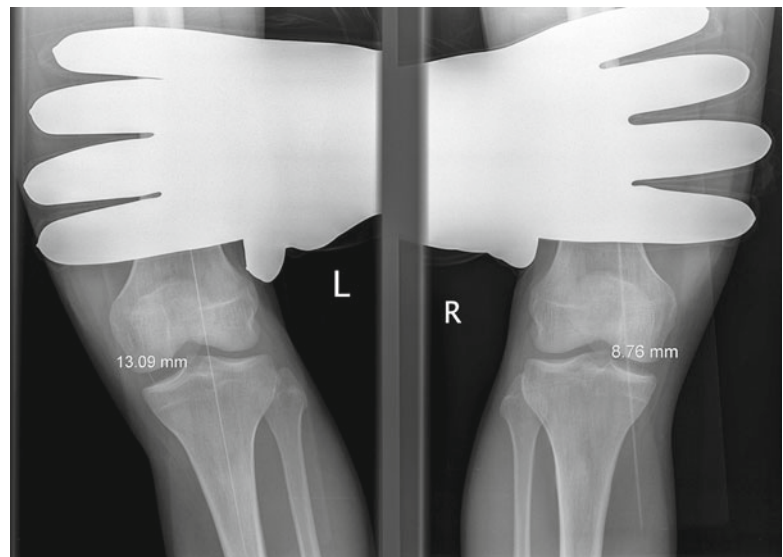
Valgus stress radiographs of an injured left knee and healthy right knee demonstrating greater than 4 mm side-to-side difference in gapping with a valgus stress applied
